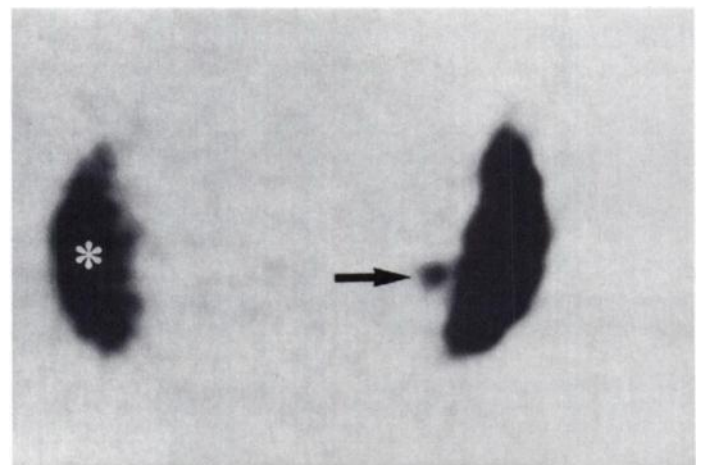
Technetium-99m-HDRBC SPECT image. Clear accumulation of radionuclide is seen at the site in question (arrow). A fair amount of liver uptake is also seen (white asterisk), probably due to excessive RBC damage.
